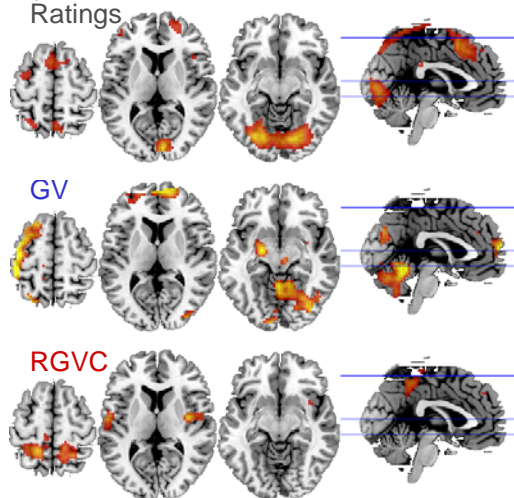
Statistical maps of brain activation components for the 700-ml balloon distention paradigm. Ratings: highlights brain regions involved in reading questions (MRI goggles) and responding them (pressing buttons); GV: highlights brain regions that are activated by increased balloon volume; RGVC: shows brain regions sensing volume changes caused by water inflow or outflow. Sample = 22 healthy subjects.
